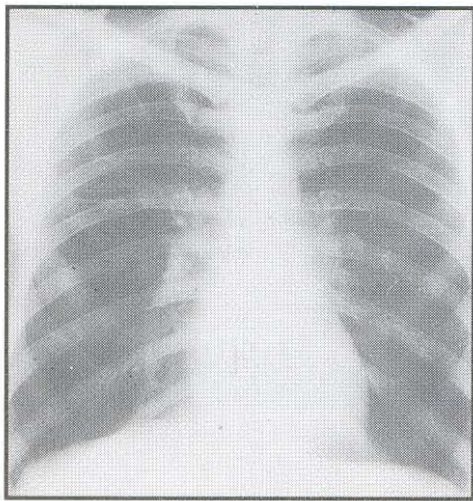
X-ray chest showing normal study.
